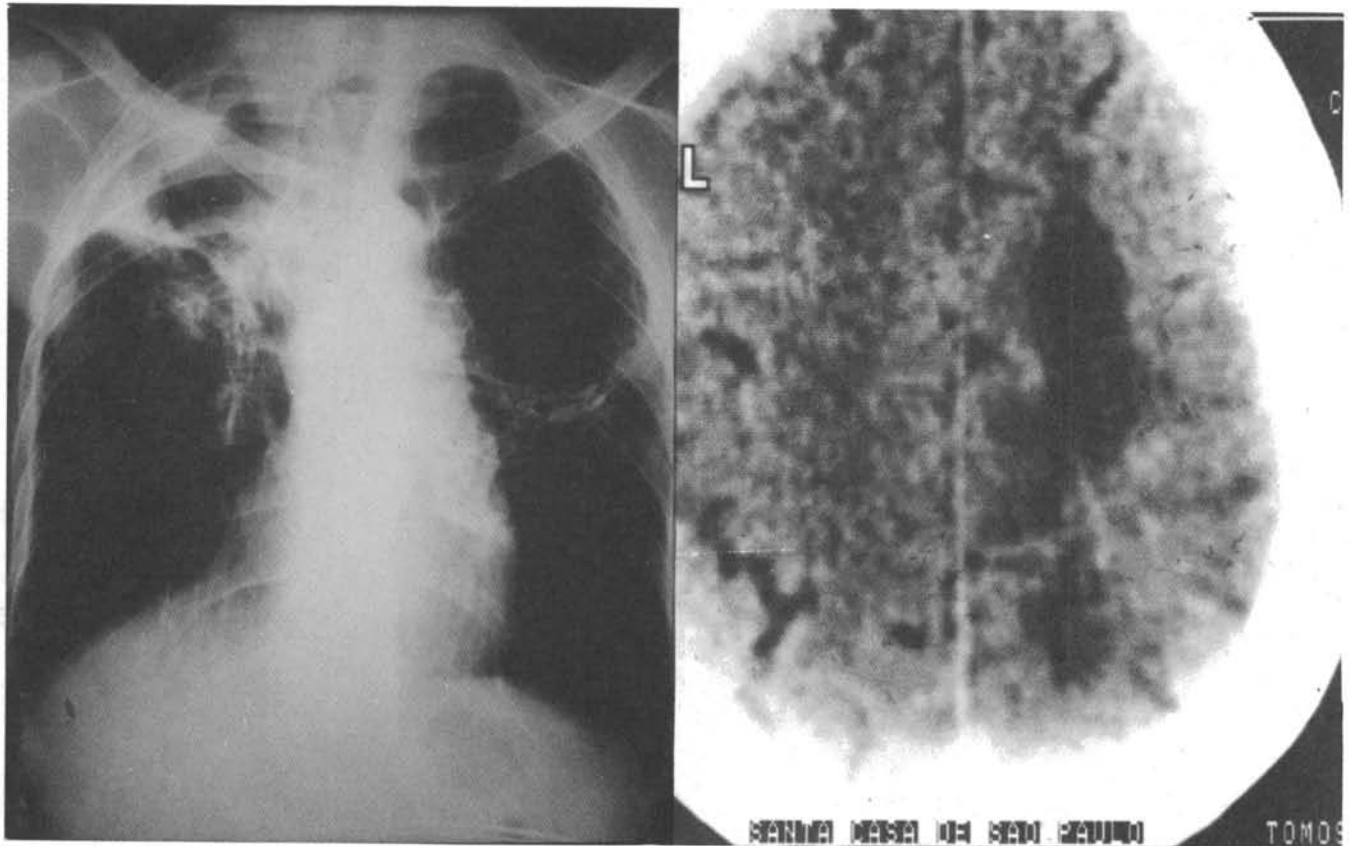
Left (A). Chest x-ray shows absence of the "Fungus Ball". Right (B). Computed tomography shows involution of both abscesses, an area of decreased density only in the right parietal lobe, without a shift of the midline structures.
